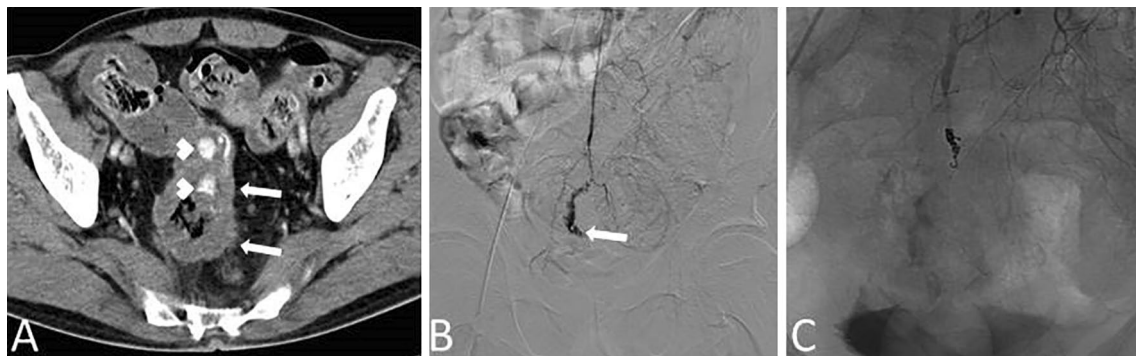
48-year-old male patient presenting with hematochezia. A Axial post-contrast CT image shows diffuse wall thickening of the rectum (arrows) and contrast media extravasation into the lumen consistent with active bleeding (arrowheads). B DSA image shows active
